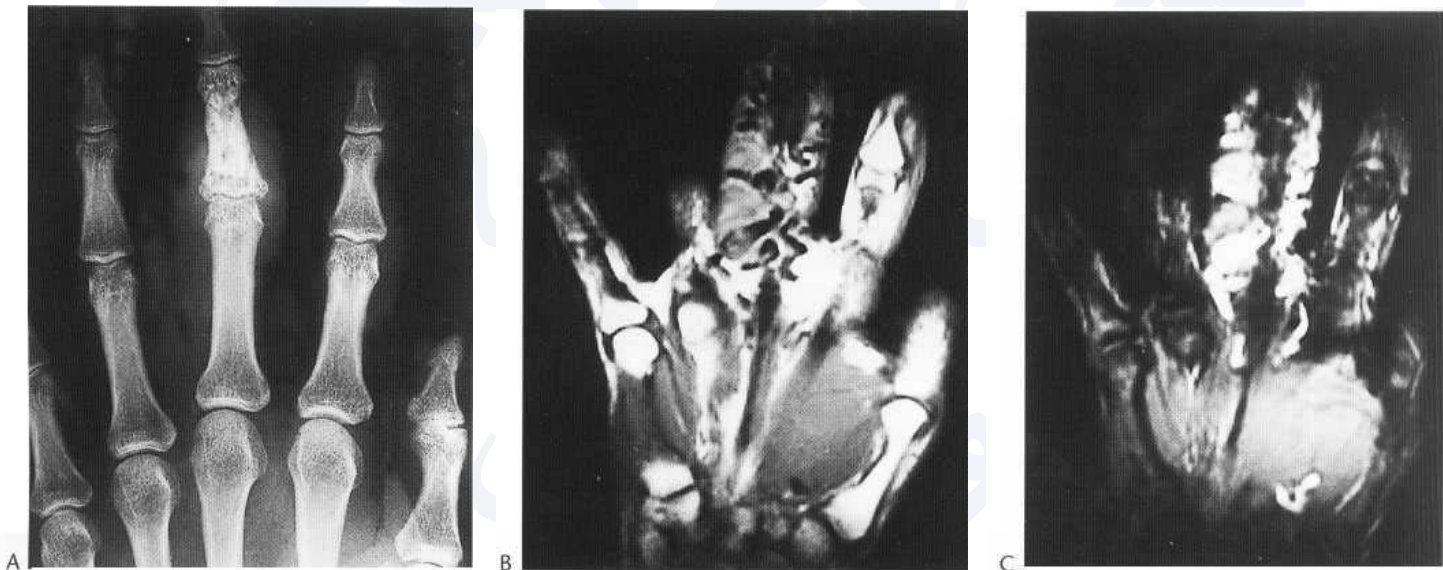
Haemangioma of the middle finger middle phalanx with associated prominent soft-tissue component. (A) Conventional radiograph showing sclerotic striated phalanx of the middle finger and soft-tissue swelling. Coronal T_1 -weighted (B) and gradient-echo (C) MR images showing the extensive soft-tissue component of the cavernous haemangioma. The dilated abnormal vessels and vascular spaces appear as characteristic low-signal serpiginous channels on the T_1 -weighted sequence but have a high signal intensity on the gradient-echo image.
